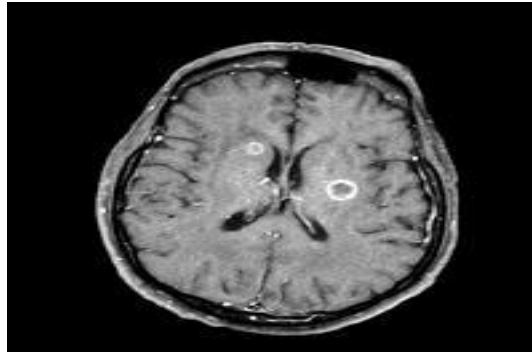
Figuer (2-17): MRI brain axial gradient echo(Ronald L.Eisenberg Nancy M. Johnson ,Comprehensive Radiographic Pathology)
